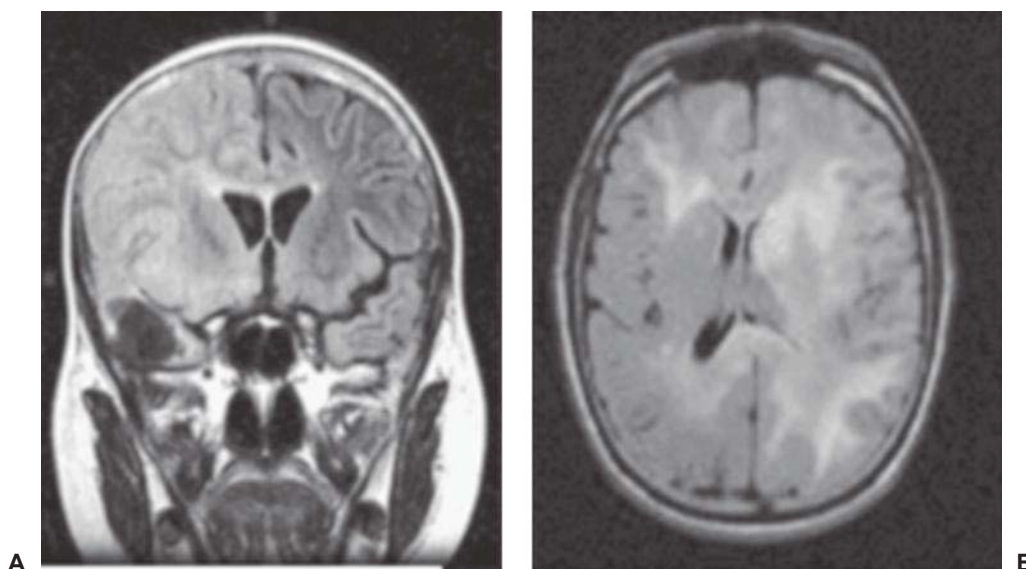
Two case examples of gliomatosis cerebri. Note the extensive changes visualized on fluid-attenuated inversion recovery (FLAIR) imaging, involving multiple lobes of the brain, and even an entire hemisphere.
